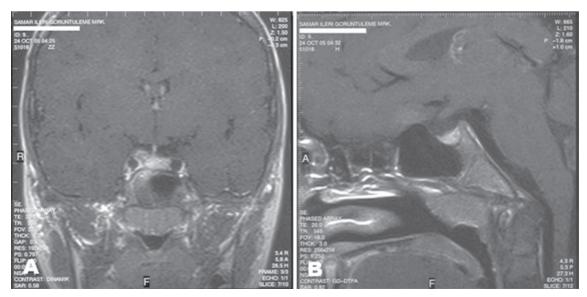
Repeat MRI of the pituitary after six months of levothyroxine treatment. T₁-weighted coronal (A) and midsagittal (B) images show complete resolution of the pituitary enlargement.
